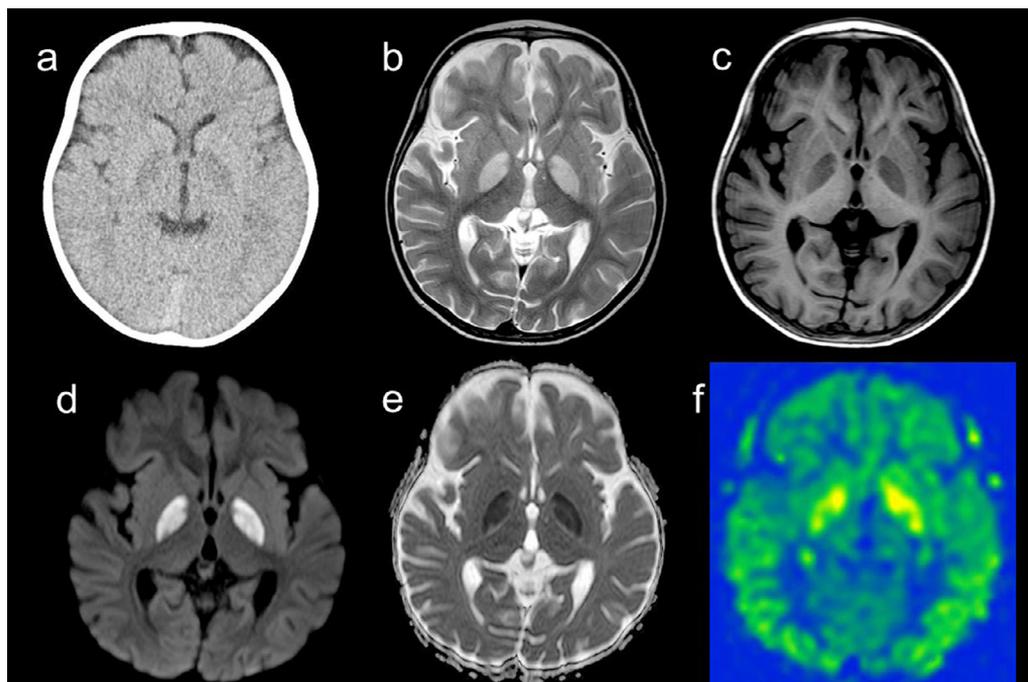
Brain CT on day 1 and MRI on day 7. CT (a) showed hypodensity lesions in the bilateral globus pallidus. T2-weighted (b) and T1-weighted (c) images show high and low signals in the bilateral globus pallidus, respectively. A diffusion-weighted image (d) reveals a high signal with reduced ADC (e) in the globus pallidus. ASL (f) shows hyperperfusion in the bilateral globus pallidus.
